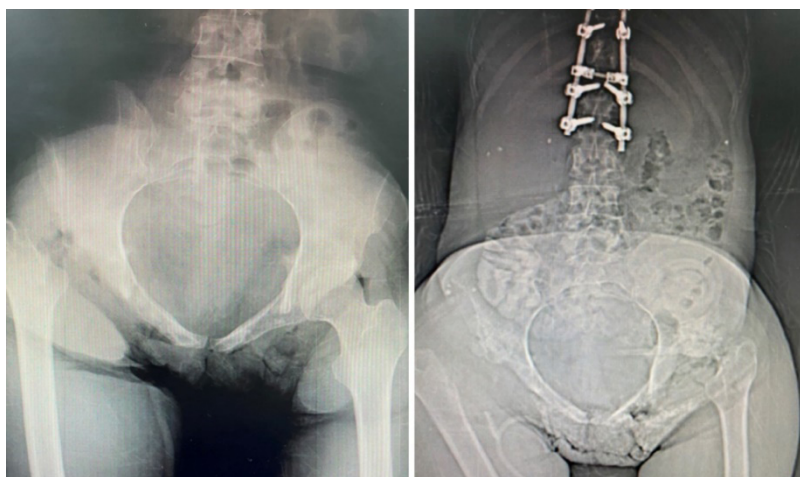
X-ray films of pelvis and hip in antero-posterior view. Left: the undiagnosed right hip fracture. Right: the hip after the right femoral head resection and colostomy.
